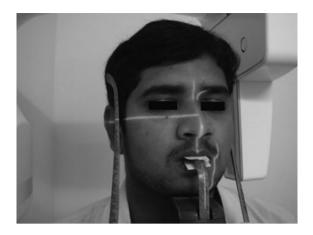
Patient positioned for panoramic radiograph.
